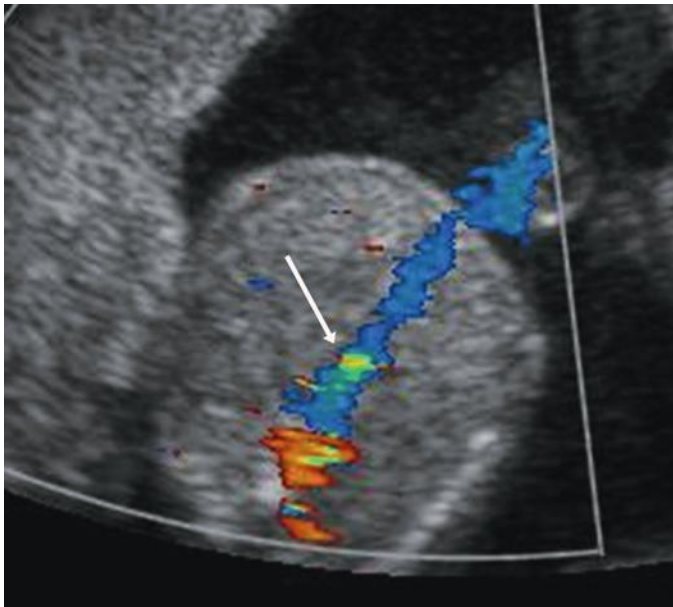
High scale settings best reveal high-velocity flow with aliasing in the ductus venosus (arrow) on this transaxial color Doppler ultrasound image through the fetal upper abdomen.
